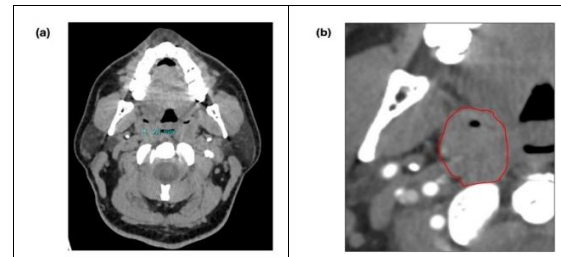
CT imaging of the 46-year-old patient, 20 hours after the spontaneous tonsillar hemorrhage (a) CT angiography of the right pharyngeal region, the blue line indicates a 2.1 mm tonsillolith. (b) CT angiography showed a tonsillar abscess formation, and no arterial malformation was observed.
